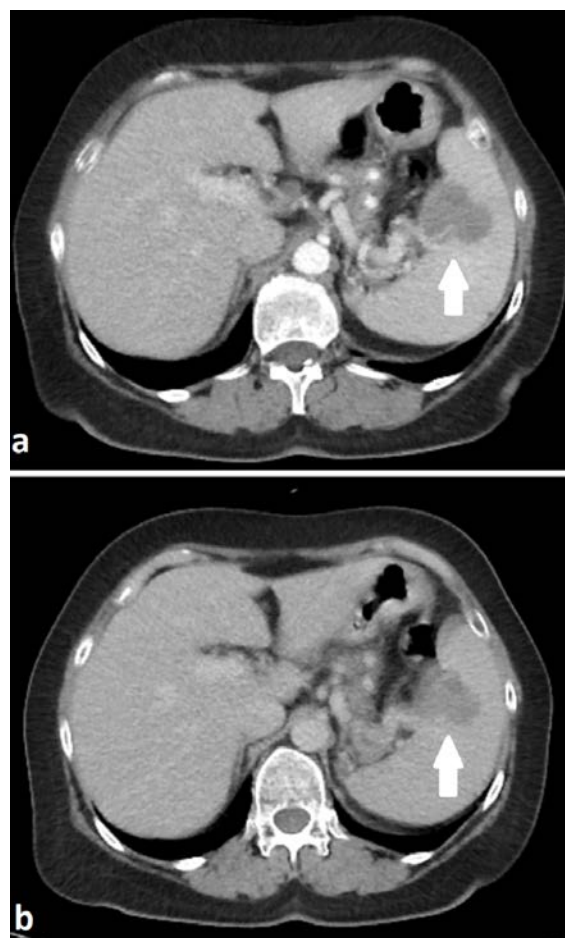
Contrast-enhanced axial computed tomography scans of the upper abdomen with the arrow indicating the splenic tumor: a – arterial phase; b – delayed phase.
